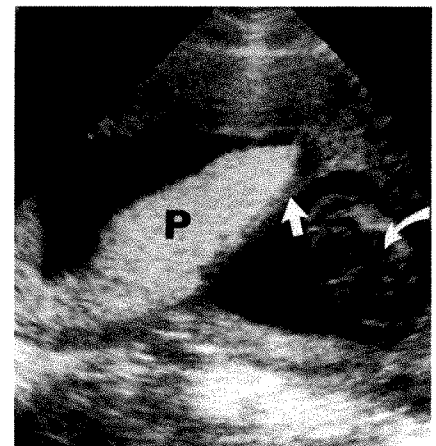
Benign shelf at 16 weeks. Sagittal sonogram shows placenta (P) extending well onto shelf (straight arrow) in this patient. This shelf was in lower uterine segment and extended transversely across uterine cavity. This was only case with a fetal anomaly; abnormal cerebral tissue (curved arrow) due to anencephaly is seen.
